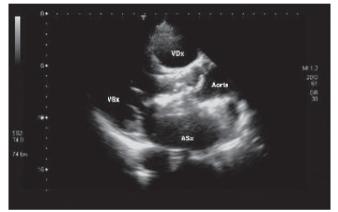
Transthoracic echocardiography, showing the filamentous vegetation adherent to the cusps of the prosthesis, fluctuating in the ascending aorta.
